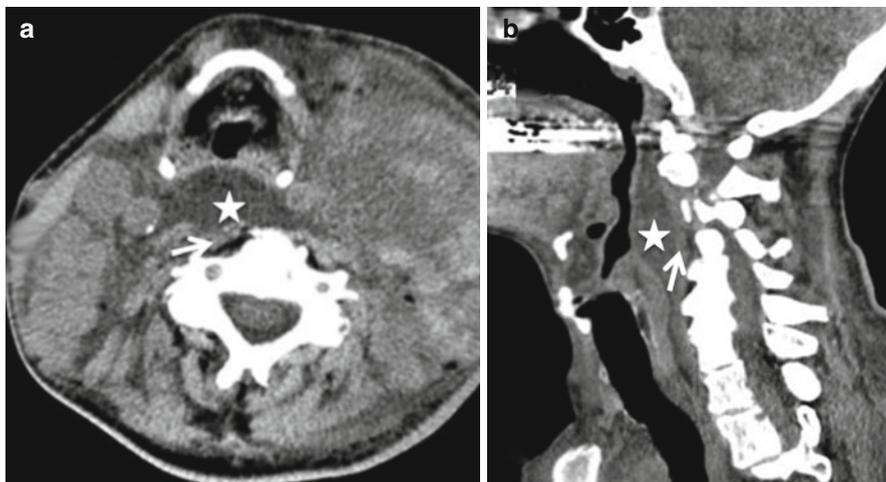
Retropharyngeal edema. Axial and sagittal CT images (a, b) show large retropharyngeal effusion (*white star*) in this patient with bilateral pathological adenopathy status postradiation therapy. This is not an uncommon situation and retropharyngeal effusions have been described in various other infectious and inflammatory conditions. Note its location anterior to the prevertebral muscles (*small white arrows*)
